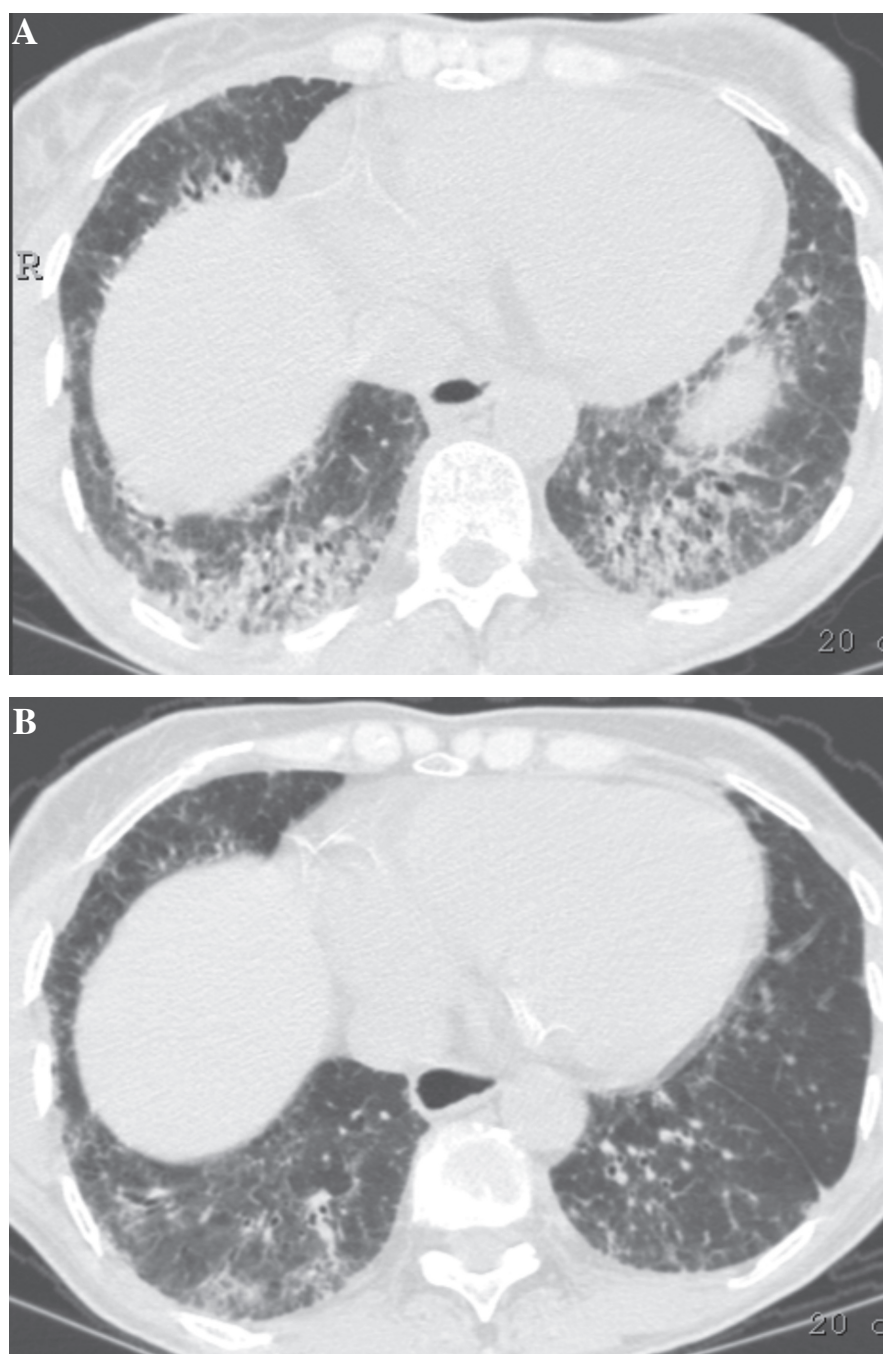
Chest HRCT performed at baseline (A) and 12 months after therapy (B) at the level of the liver dome in a 55-year old woman suffering from SSc-associated active interstitial lung disease. Ground-glass opacities were graded 4 (between 76 and 100% of the surface) and 3 (between 51 and 75%) at baseline and after treatment, respectively. Note the presence of mild interlobular thickening on the two HRCT examinations.
